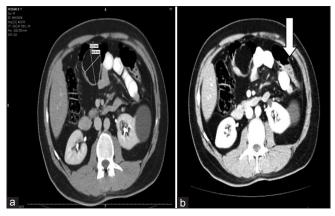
(a) Abdominopelvic computed tomography scan. A lipoma in the transverse colon just distal to the hepatic flexure. (b) Mild-concentric wall thickening at the distal portion of the descending colon, an evidence of colocolic intussusception (arrow)
